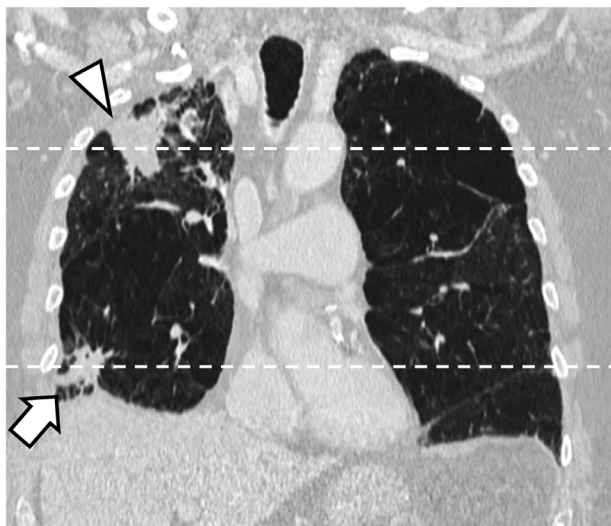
Coronal CT in lung window setting shows pulmonary nodules in right middle (Arrow) and right upper lobes (Arrowhead) which based on size and morphology appear similar and suspicious for malignancy.
